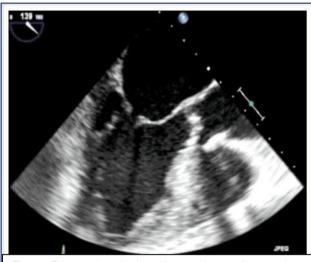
Transesophageal echocardiogram demonstrating normal anatomy of a mitral valve
